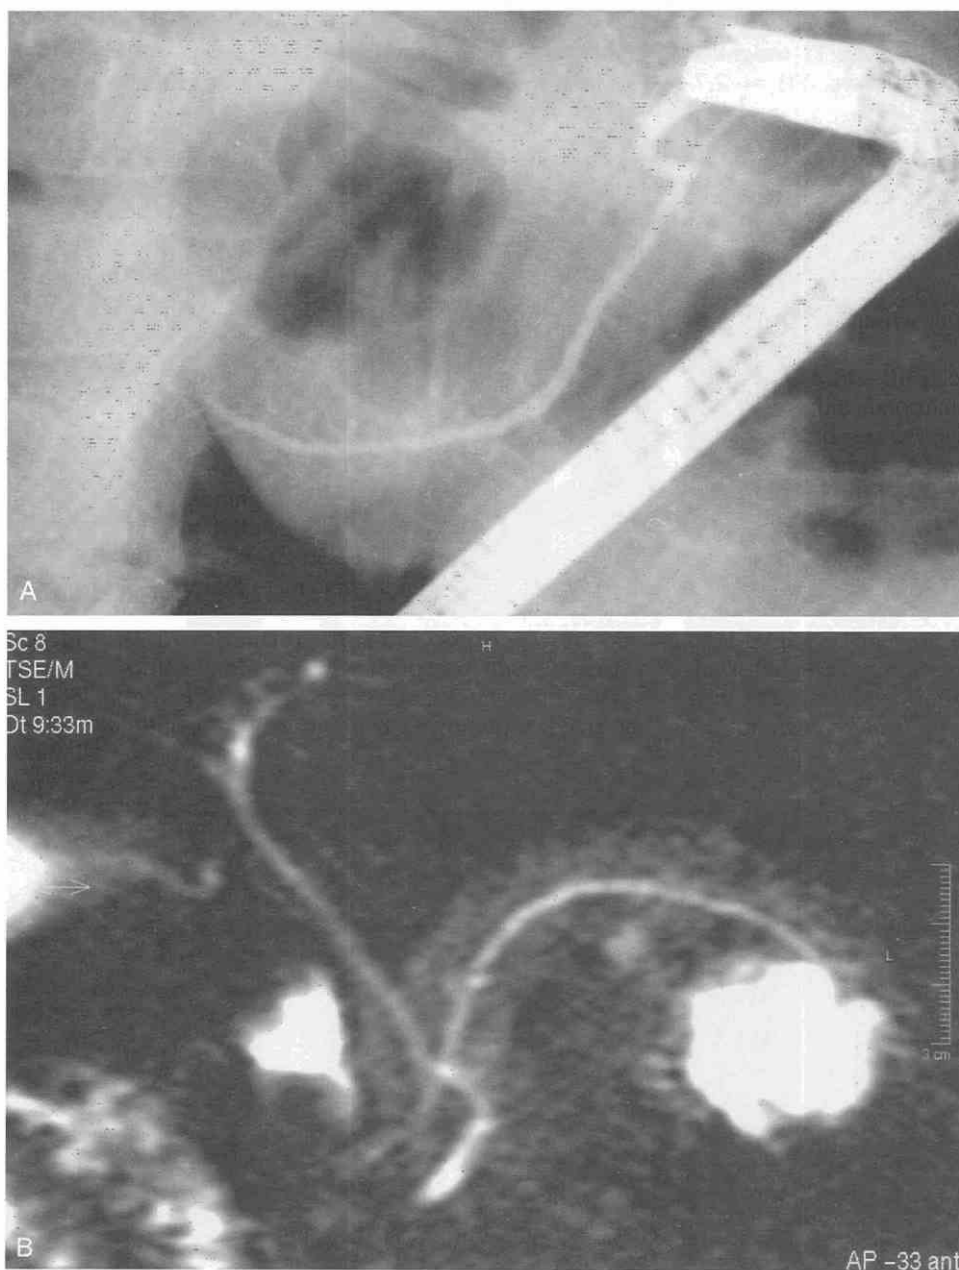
A, Pancreatic duct during endoscopic retrograde cholangiopancreatography (ERCP). B, MR cholangiopancreatogram (MRCP) showing acinar filling. (From Matos C, Deviere J, Cremer M, et al: Acinar filling during secretin-stimulated MR pancreatography. *AJR Am J Roentgenol* 171: 165-169, 1998.)
